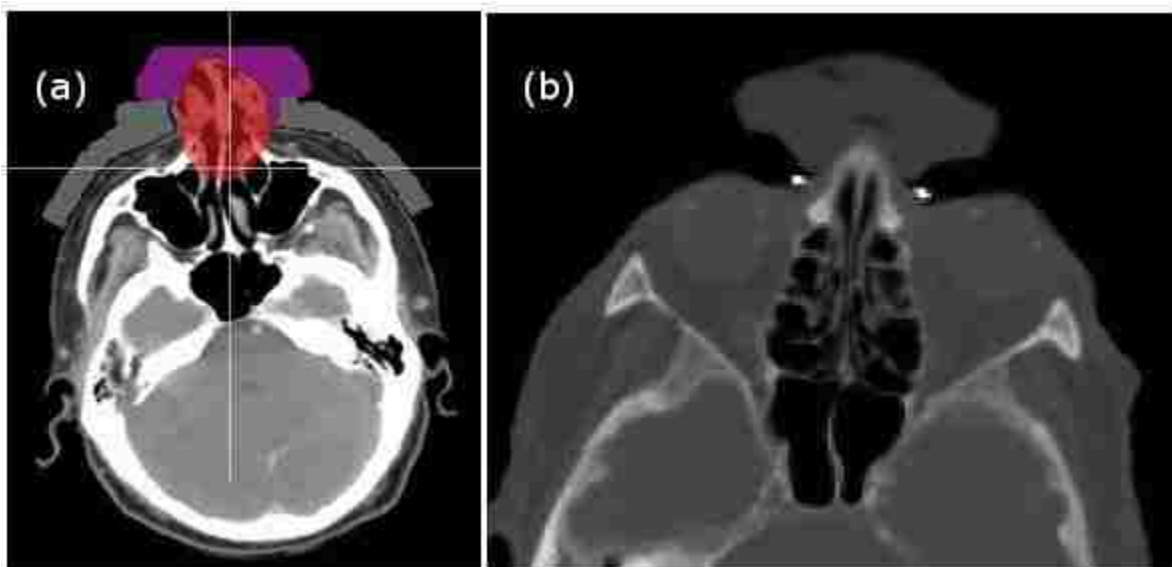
Boluses for nasal cavity patients are shown. On the left is patient 4 (a) that has a hand contoured water equivalent bolus seen in purple with a 1.0 cm lead equivalent skin collimation seen in gray. On the right is patient 5 (b) with the CT scanned bolus on the patient before the lead skin collimation was added.
